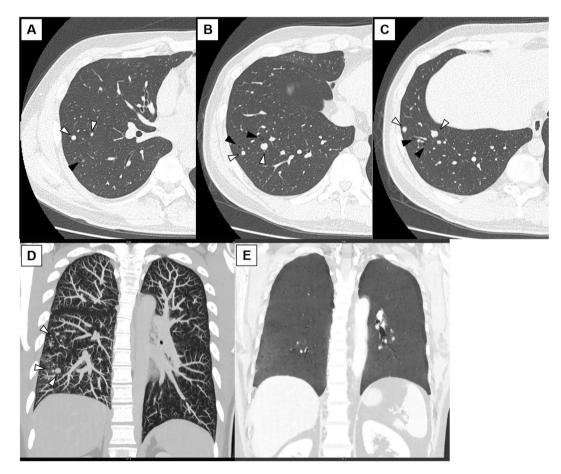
A-C) Preoperative chest HR-CT image shows multiple 1-to-8-mm round nodes (white arrowheads). The black arrowheads indicate sporadic pulmonary cysts. These findings were limited to the right lower lobe, but they were not aggregated. D) The maximum intensity projection (MIP) reformation and E) the minimum intensity projection (MinIP) reformation of post operative HR-CT. The white arrowheads indicate residual nodules in the right lower lobe. Mosaic perfusion was not demonstrated.
